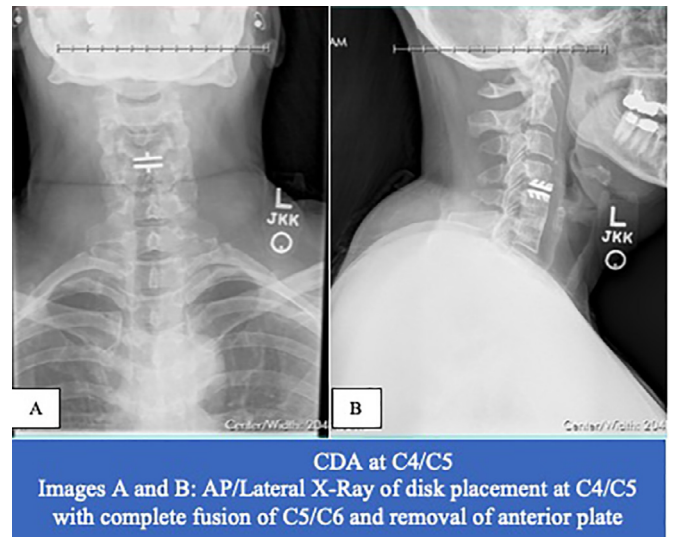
CDA at C4/C5 Image A and B: AP/Lateral X-Ray of disk placement at C4/C5 with complete fusion of C5/C6 and removal of anterior plate.
